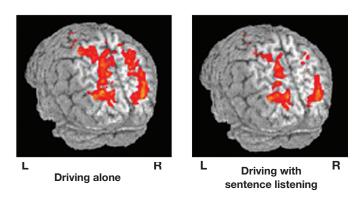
Functional magnetic resonance imaging images.
